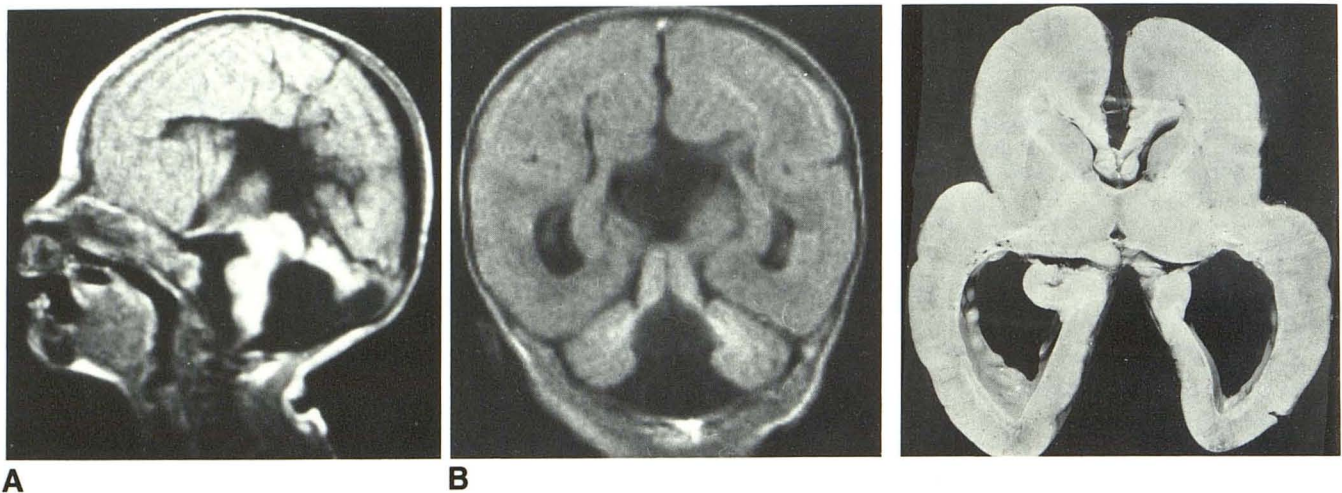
Sagittal (A) and coronal (B) MR images, 500/30, show almost completely agyric brain with absence of corpus callosum and Dandy-Walker cyst.
